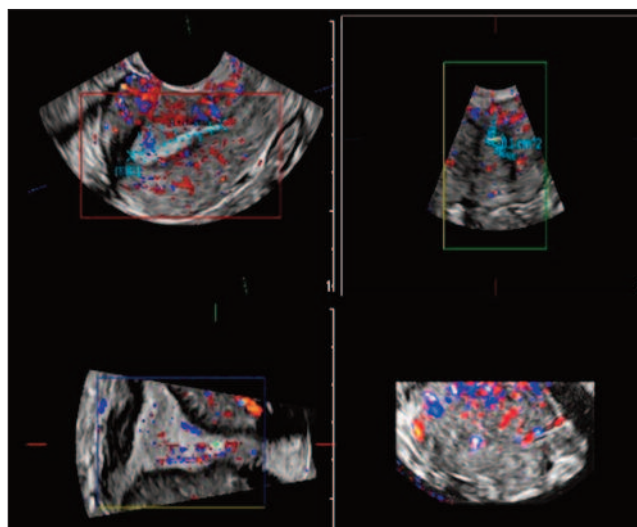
Transvaginal three-dimensional (3D) ultrasound acquisition.
